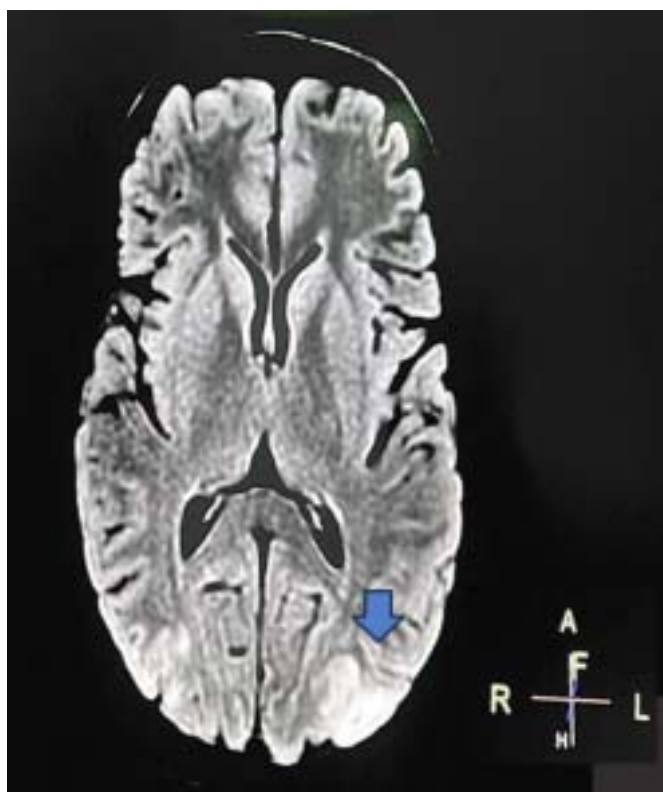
FLAIR MRI : cortical – subcortical hyperintense lesions in parieto-occipital region
